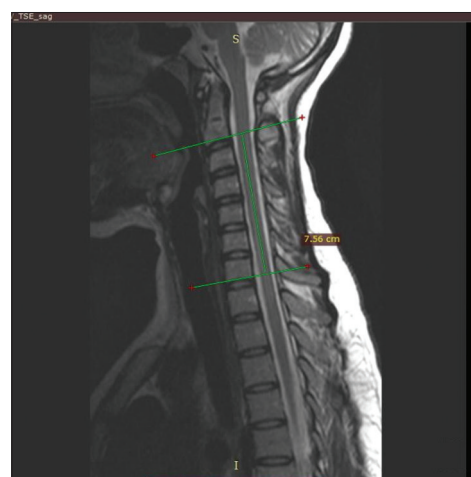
Mid sagittal T2-weighted magnetic resonance image, assigning the levels.
